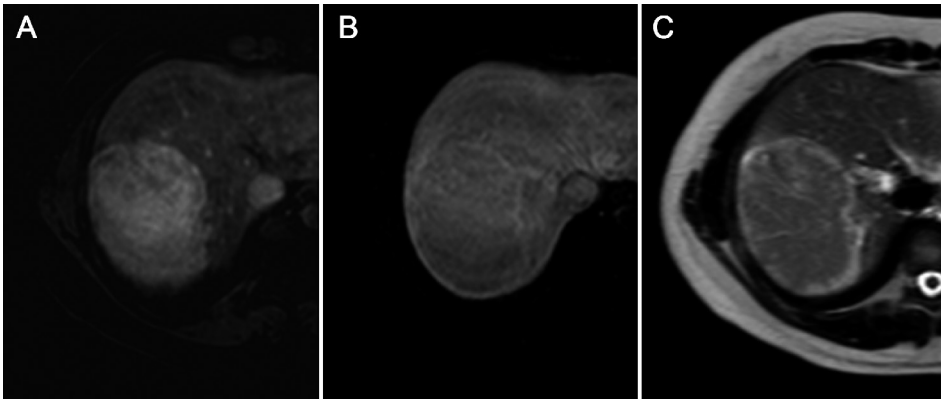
(a) Arterial- and (b) late vascular-phase dynamic contrast-enhanced T1-weighted transverse MR images. (c) T2-weighted MR image shows characteristic atoll sign of an inflammatory HCA in segment 6/7, which includes a T2-hyperintense signal band in the periphery of the lesion (like an atoll) with a center that is isointense to surrounding liver (like the surrounding sea). T2-hyperintense region typically enhances in the (b) late vascular phase, possibly corresponding to dilated sinusoids within inflammatory HCA.
